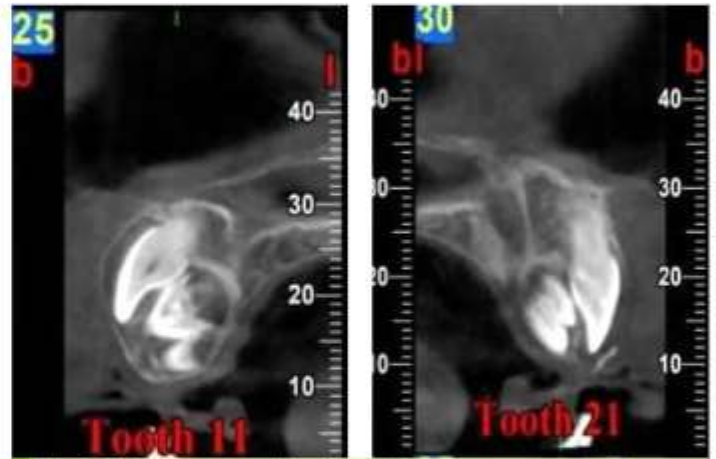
CBCT image revealing developing supernumerary teeth in relation to 11 and 21
